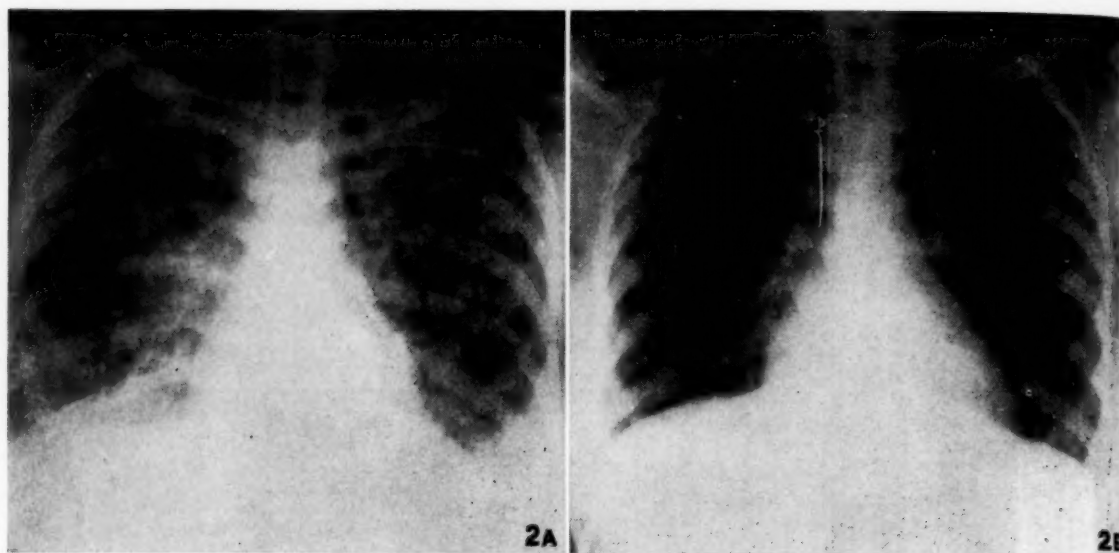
(a) Chest X-ray of case 3 taken 4 days after onset of respiratory symptoms. Extensive bilateral mottling of both lung fields is clearly visible. (b) Chest X-ray 8 days later.
